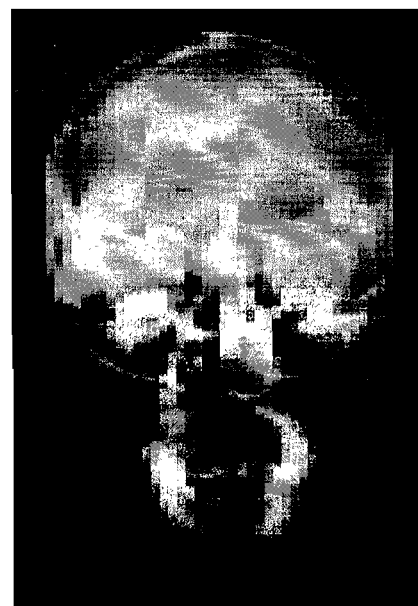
Radiograph of a cylindrical bullet in the orbit of one of the conflict victims.
